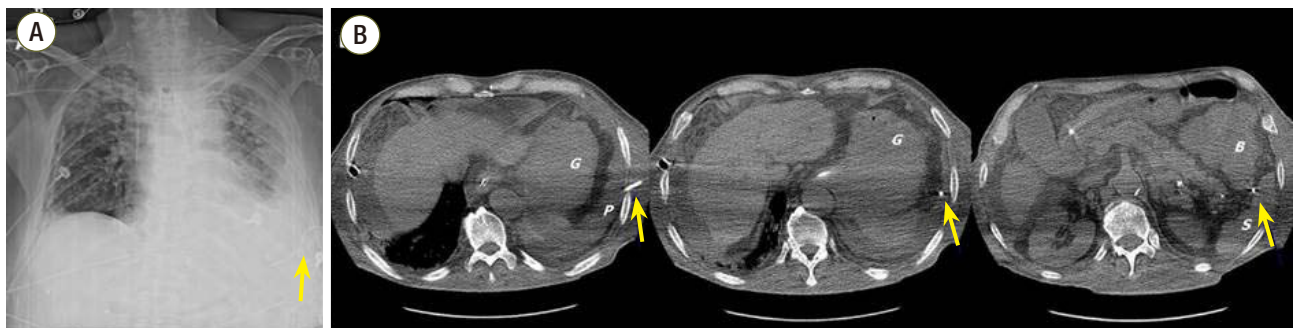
(A) Chest radiography showed the pleural catheter directed downward, marked with arrow. (B) Computed tomography scan showed that the catheter first entered into the pleural space, passed through diaphragm and the tip was located in the abdominal cavity, marked with arrows. G: stomach; P: pleural effusion; B: bowel; S: spleen.
